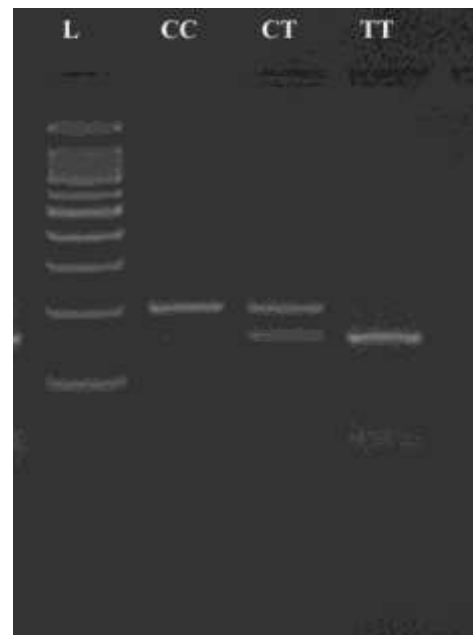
Electrophoresis pattern after enzymatic digestion, rs11544374 polymorphism of Apelin receptor gene. Genotype CC (215 bp), Genotype CT (215+150+50 bp) and Genotype TT (150+50 bp) L: Ladder: 100 bp.
